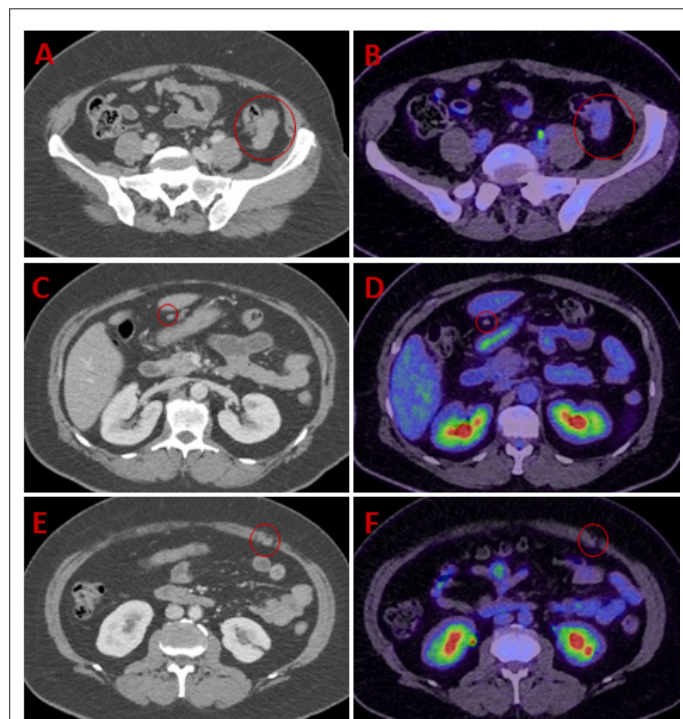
(A & B) show contrast enhanced CT and [^{18}F]FDG PET/CT images of a lesion in close proximity to the descending colon respectively, with (C & D) showing a small perihepatic nodule and (E & F) showing a small deposit within the left abdominal wall.
